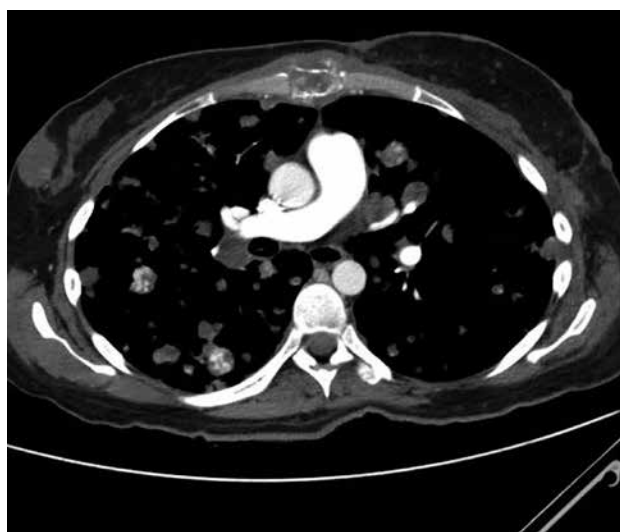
Metastatic angiosarcoma. Computed tomography pulmonary angiogram. Left breast mastectomy with myocutaneous flap reconstruction for previous angiosarcoma. New bilateral lung nodules are noted, along with cutaneous and subcutaneous metastases involving the reconstructed left breast and the right breast.
